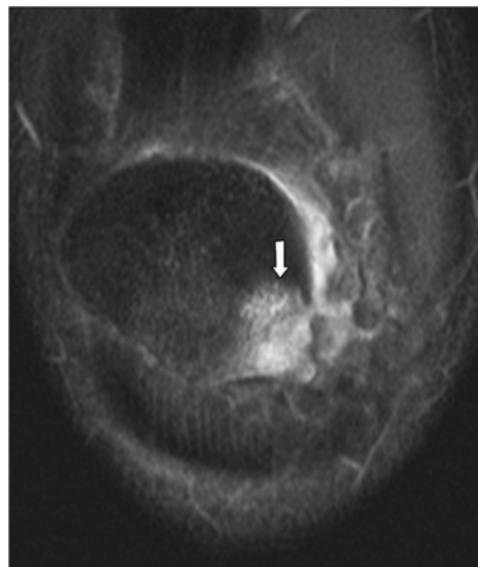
Bone edema after patellar dislocation with contusion of the patella and lateral femoral condyle. (a) Axial slightly T2-weighted fat-saturated MR image shows circumscribed edema (arrow) of the lateral condyle in a 23-year-old woman. (b) Coronal heavily T2-weighted fat-saturated MR image depicts extensive bone edema (arrow) in an 18-year-old man. (c) Coronal heavily T2-weighted fat-saturated MR image shows a bone bruise (arrow) of the inferomedial aspect of the patella in a 24-year-old man.
